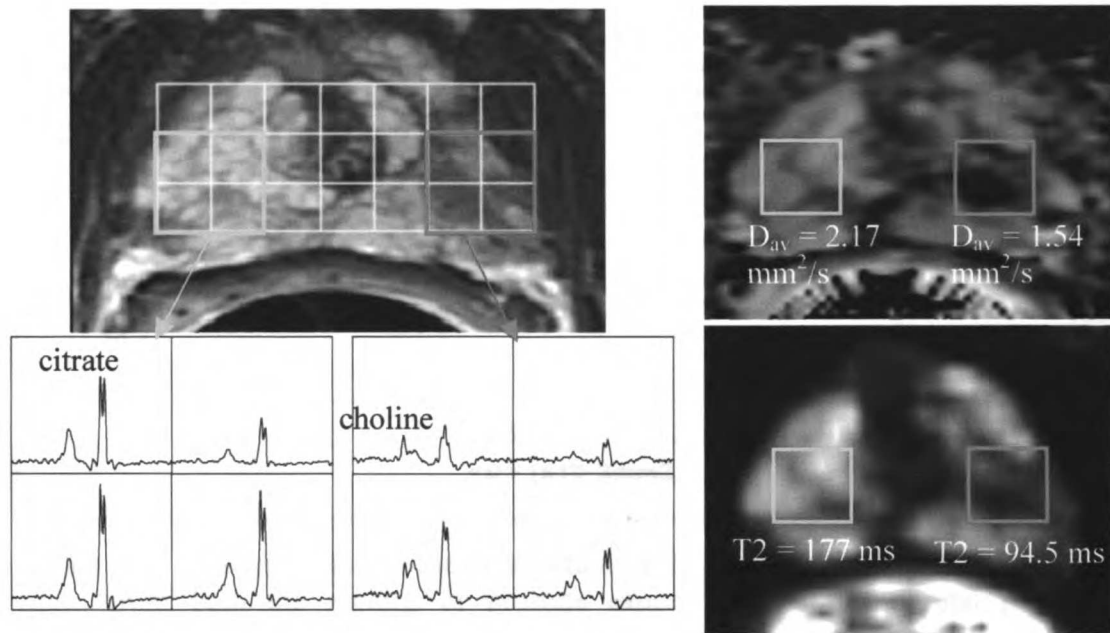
Sixty-one year old prostate cancer patient with biopsy proven cancer (G3+3, Left lobe). High-resolution T2-weighted FSE images (upper left) and MRSI (lower left) showed decrease signal intensity in the T2-weighted image and elevated choline and reduced citrate in region of prostate cancer. $\langle D \rangle$ maps (upper right) and T2 maps (lower right) also demonstrated decreased $\langle D \rangle$ (Cancer: .154 mm²/s vs Healthy: 2.17 mm²/s) and T2 (Cancer: 94.5 ms vs Healthy: 177 ms) relaxation time in region of cancer compared to region of healthy prostate peripheral zone.
